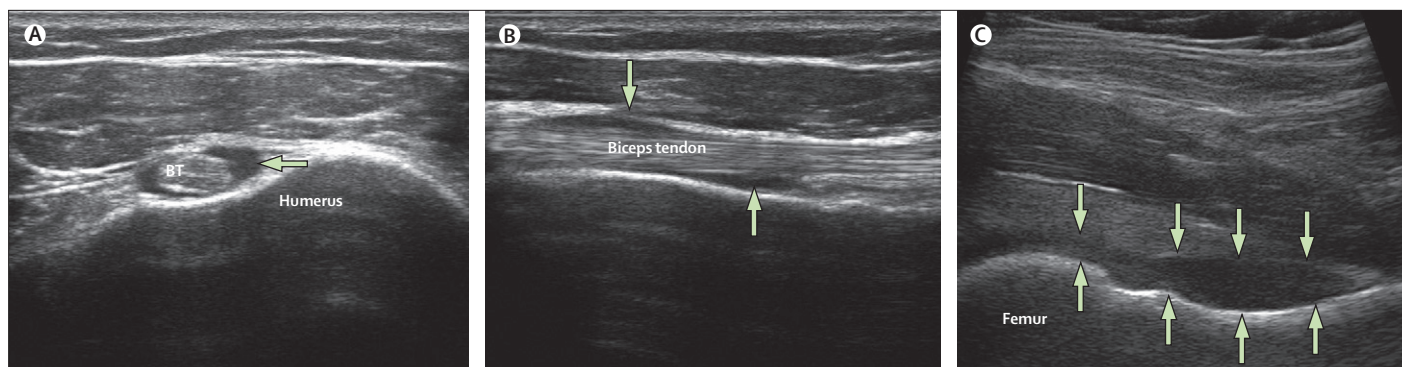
Ultrasonography of shoulder and hip in polymyalgia rheumatica
